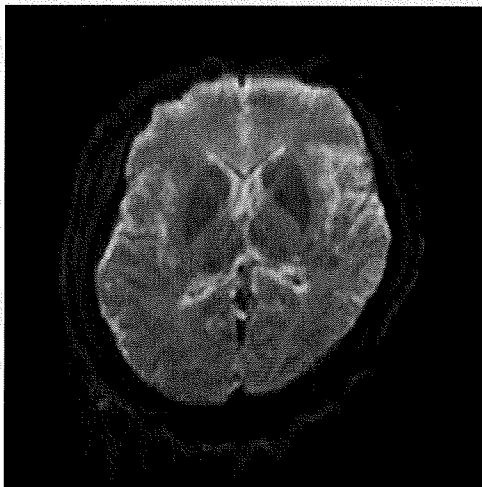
A 37-year-old woman. Postmortem MRI diffusion weighted image of the brain obtained 36 h after confirmation of death shows high signal intensity rims along the cerebral cortices and the ventricular wall
